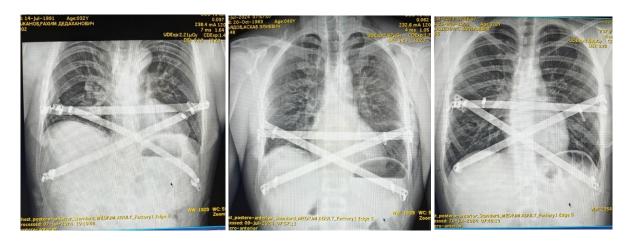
X-ray images of various patients with attached IX-bars.
